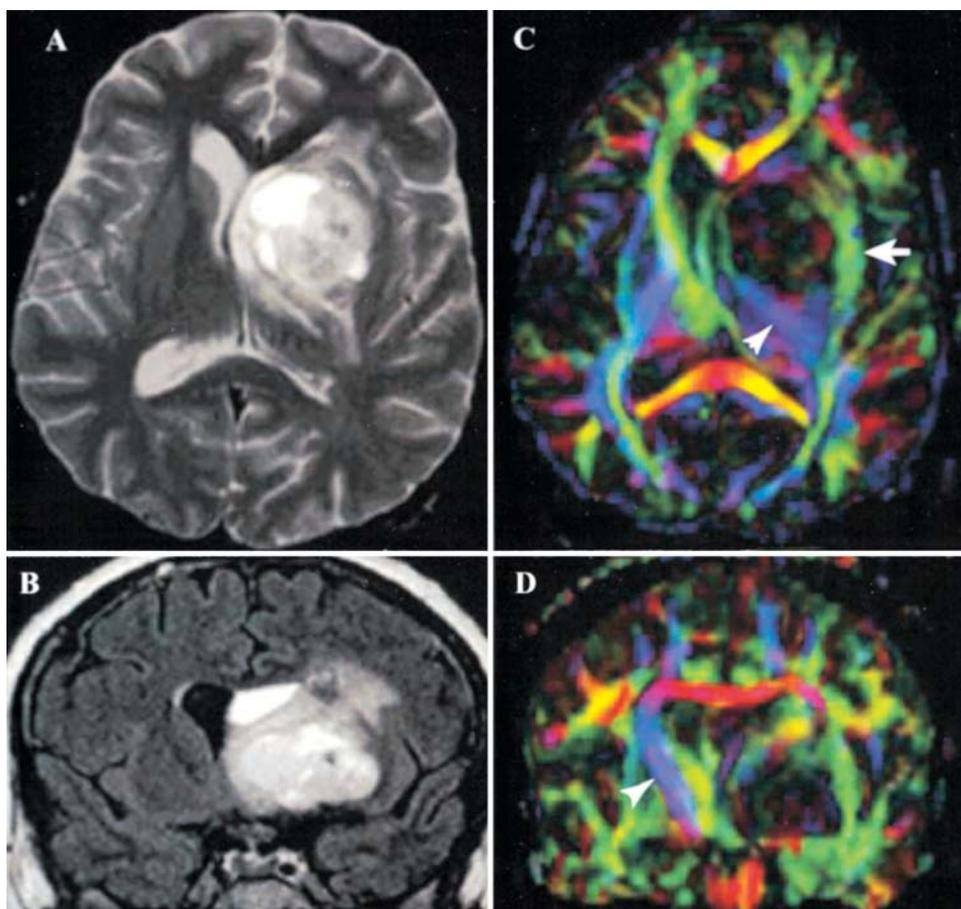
Case 5. Deviation of white matter tracts in a patient with a pilocytic astrocytoma. A: An axial T₂-weighted MR image. A large, well-circumscribed, cystic, heterogeneously enhancing lesion appears within the white matter of the left frontal lobe corresponding to the location of the lesion. B: Coronal contrast-enhanced FLAIR image at the level of the interventricular foramen demonstrating a large frontal lobe lesion eliminating the left lateral ventricle. C and D: An axial (C) and a coronal (D) DT image demonstrating signal dropout within the region of the left frontal lobe. The green fibers of the arcuate fasciculus (*arrow*) are deviated to the left, over the lateral edge of the tumor. The blue inferiorly directed corticospinal fibers within the corona radiata, (C, *arrowhead*) are deviated posteriorly and medially from their normal anatomical location. The coronal image (D) displays the intact fibers of the corona radiata (*arrowhead*) in their correct anatomical position in the unaffected right cerebral hemisphere. The corresponding fibers in the hemisphere invaded by tumor are absent at this level because of their displacement over the posterior margin of the tumor.
